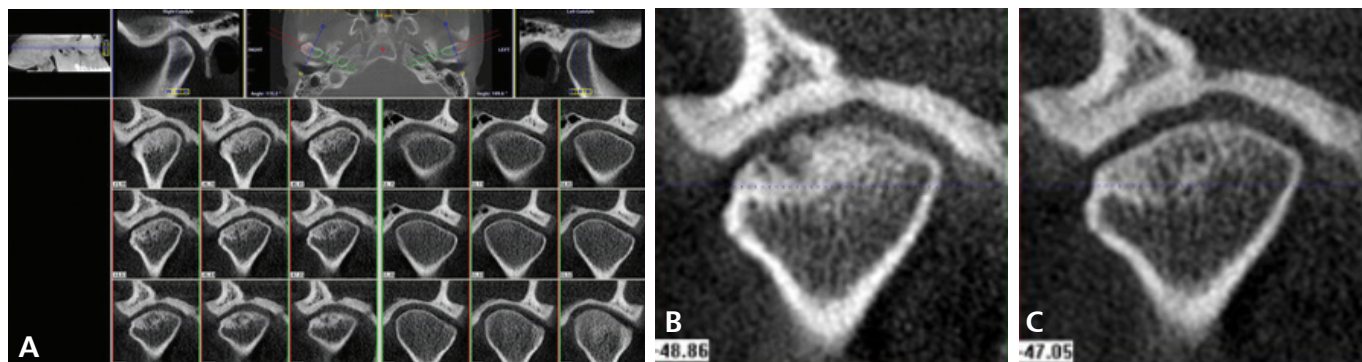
Follow-up CBCT image after two years (A), longitudinal bone change was evaluated between initial (B) and follow-up image (C) displayed restoration of erosive bony concavity gradually recovered and regained intact cortical lining of right TMJ condyle.
